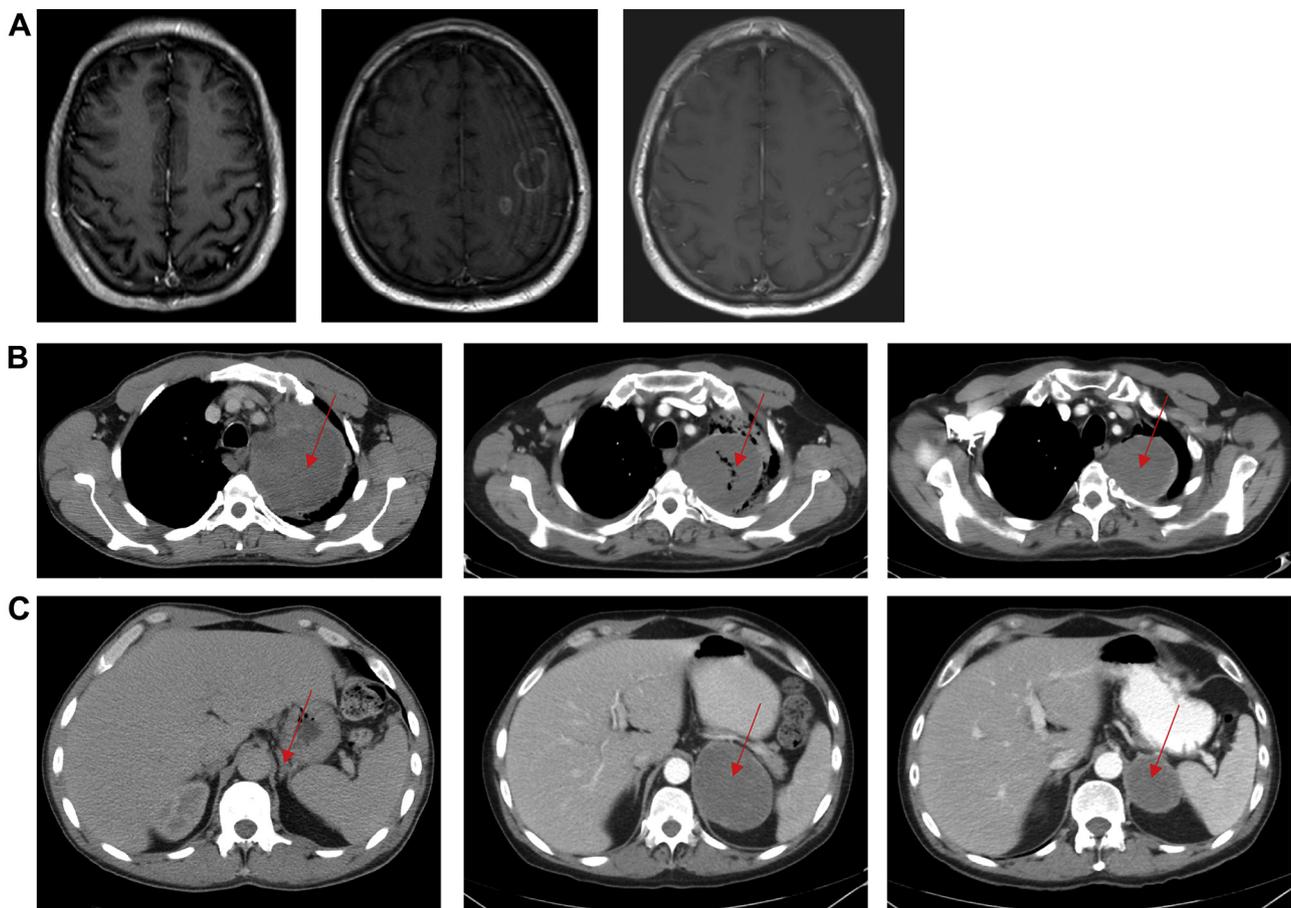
Case 2. Computed tomography (CT) scans of the patient with high tumor mutational burden and programmed death ligand 1-positive pulmonary sarcomatoid carcinoma at diagnosis (*left*), before initiation of pembrolizumab (*center*), and after 8 months of pembrolizumab therapy (*right*). (A and B) CT scans of brain (A) and lung (B) lesions, which also received radiation. At diagnosis the primary lung lesion measured $9.3 \times 10.6 \times 12$ cm (B [*left panel*]). (C) Abdominal CT scans showing the adrenal mass, which was reduced by 35% (from 89 mm to 57 mm in the largest dimension) during the course of pembrolizumab treatment (*center panel* to *right panel*).
